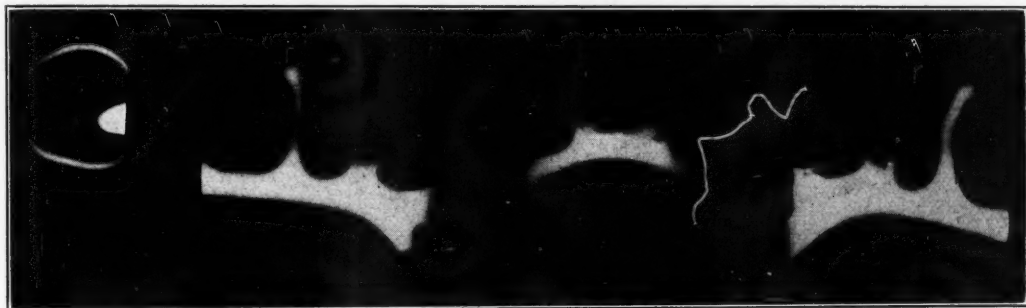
Assembled radiographs of unit casting. (Note dark line through occlusal rest in second section from left.)
